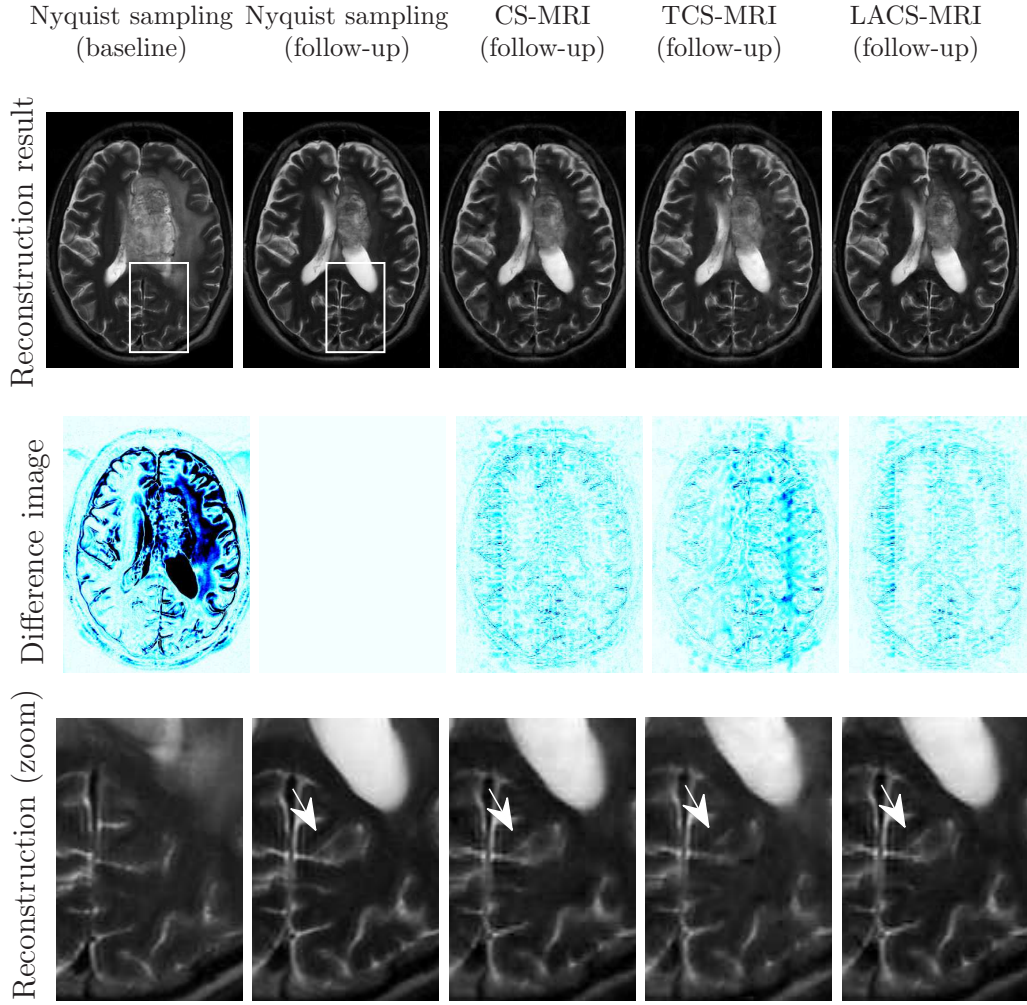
2D FSE brain imaging results when similarity between baseline and follow-up is minimal. The leftmost column shows the baseline scan used as \mathbf{x}_0 for TCS-MRI and LACS-MRI. The difference image between the baseline and the follow-up scans shows substantial changes due to rapid tumor changes. The last row shows an enlargement of the white rectangle. LACS-MRI and CS-MRI exhibit similar results, where TCS-MRI exhibits sub-optimal results in the changes regions, due to its wrong assumption of substantial between the baseline and the follow-up scans.
